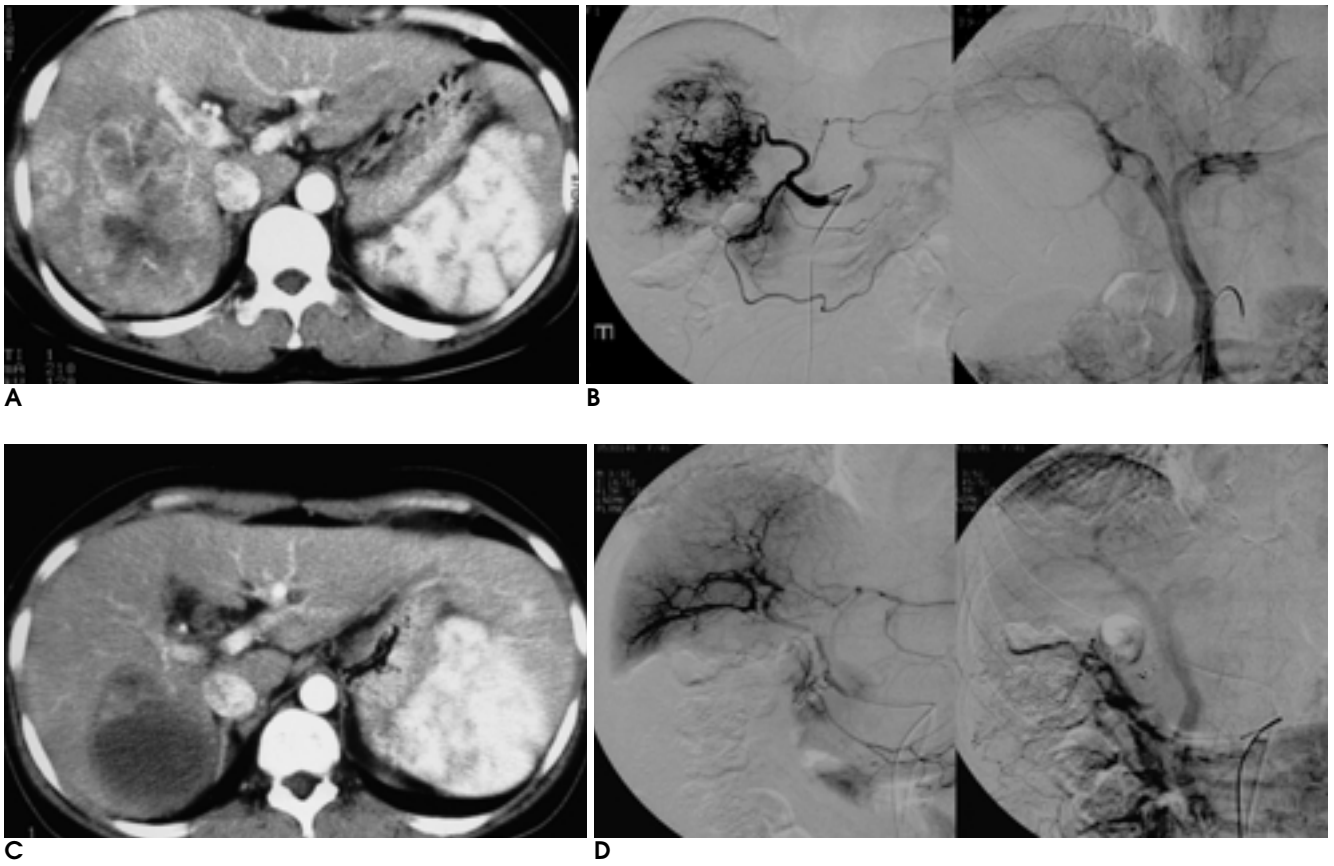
A 56-year-old man has massive HCC on right lobe with portal vein thrombosis and arterio-portal shunt (A, B). Follow up CT scan after 10 month shows decreased tumor size with necrosis. Angiography shows disappearance of portal vein thrombosis and arterio-portal shunt (C, D).
